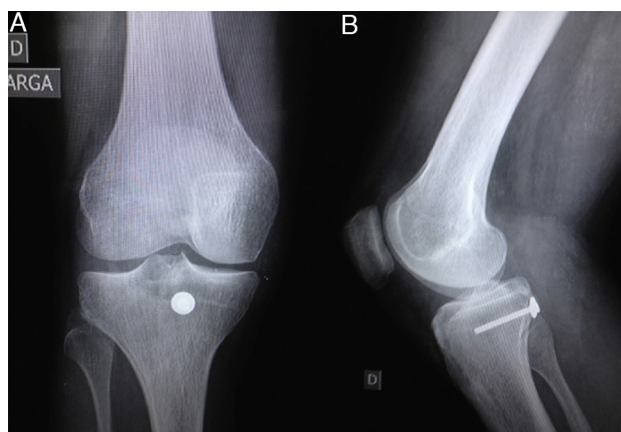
Postoperative radiography of the right knee (A) AP view and (B) profile view.
